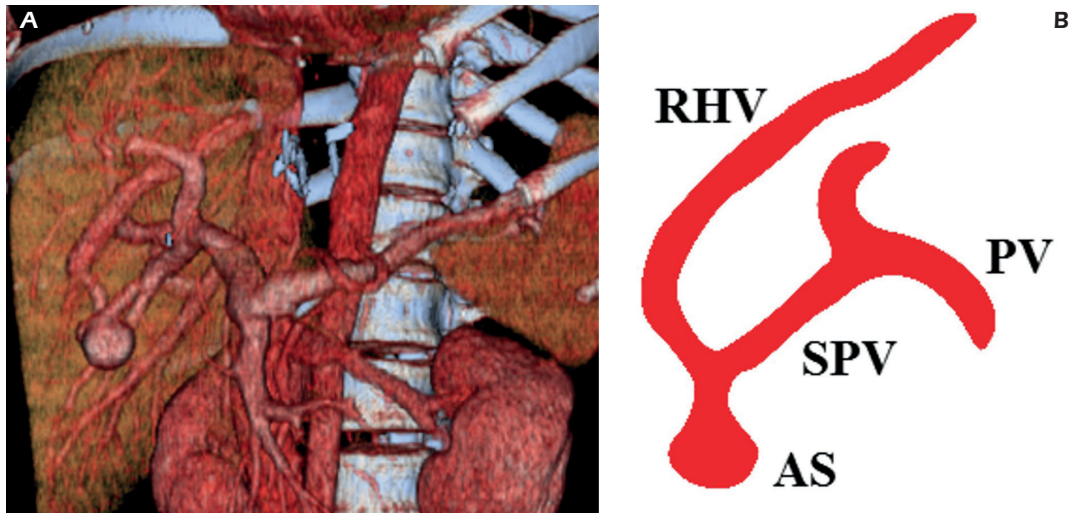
Intrahepatic portosystemic shunts - type 3. A, CT shows an aneurismal shunt in the VI hepatic segment in a subcapsular location. Volume rendering 3D reconstruction shows the afferent portal branch and efferent hepatic vein drainage of the aneurismal intrahepatic portosystemic venous shunt. B, PV: portal vein; SPV: segmental portal vein; RHV: right hepatic vein; AS: aneurismal shunt
